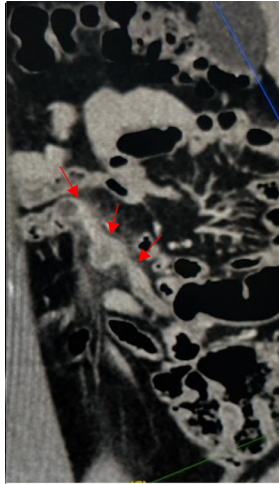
Sagittal contrast CT image shows the wall enhancing tubular lesion (shown by the red arrows).
